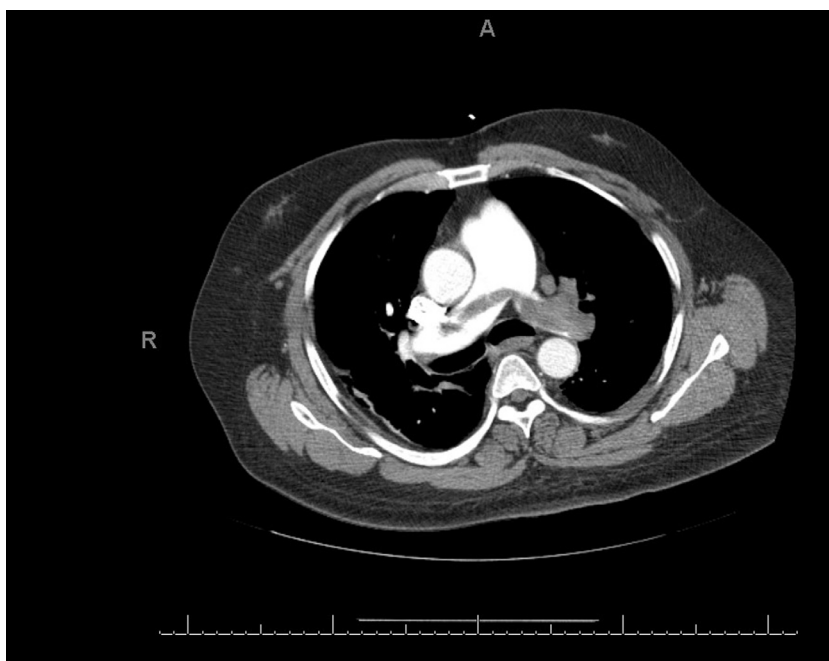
Computed tomography angiography (CTA) showing pulmonary embolus in the right main pulmonary artery.
